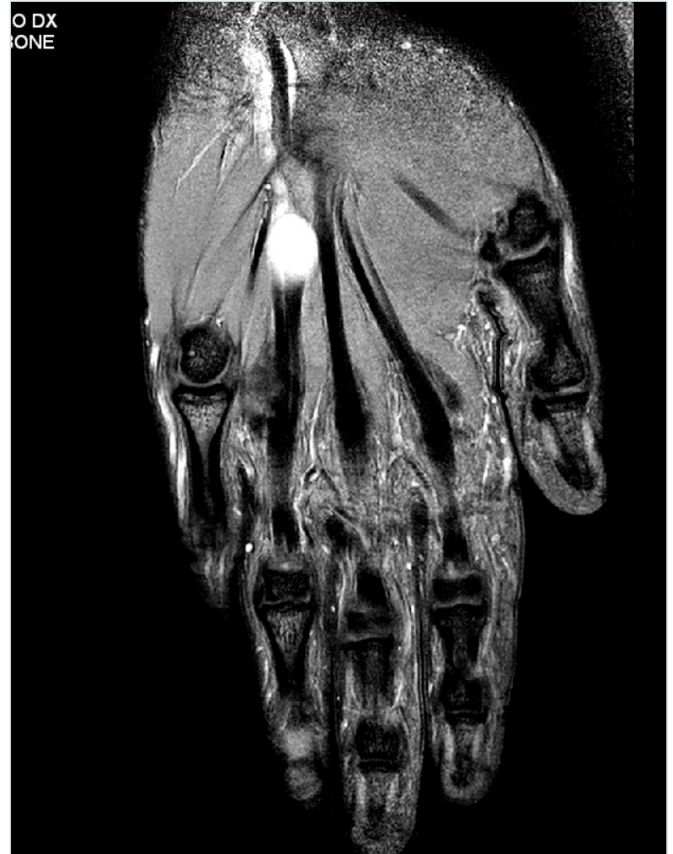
Contrast-enhanced preoperative magnetic resonance image: multinodular formation along the course of ulnar nerve.
